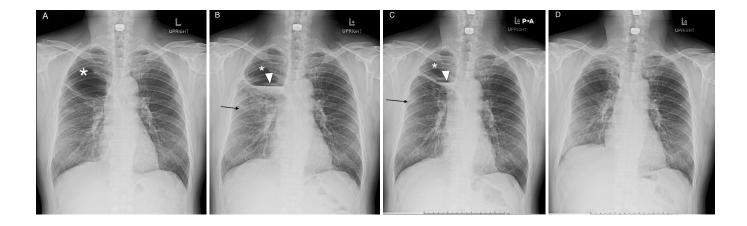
Baseline chest radiograph (A) in 2011 indicated to work up the secondary cause of his arthralgia, an asymptomatic lung bulla (asterisk) is seen as an air-filled cavity, about 10.2x8.9 centimeters in size, at the RUL. The workup chest radiograph for the right pleuritic chest pain in September 2012 (B) shows a newly seen patchy opacity at RUL (arrow) and a new air-fluid level in the previous bulla in the RUL (arrow head). The diagnosis of pneumonia with an infected bulla at RUL is made. The follow-up chest radiograph after two weeks of antibiotic treatment (C) shows the decreased RUL bulla's size from the baseline (asterisk) that was about 8.4x8.3 centimeters in dimension, and a decreased amount of internal fluid (arrow head), suggestive of spontaneous partial regression of the bulla. Also, a noted disappearance of patchy opacity at RUL, likely resolved pneumonia (arrow). Finally, after discussion with cardiothoracic surgeon about the residual bulla, this patient underwent RUL lobectomy three months later without a serious post-operative complication. The post operative follow-up chest radiograph in January 2013 (D) reveals the right apical pleural thickening of surgical change and no residual bullae with mild decreased right lung volume.
